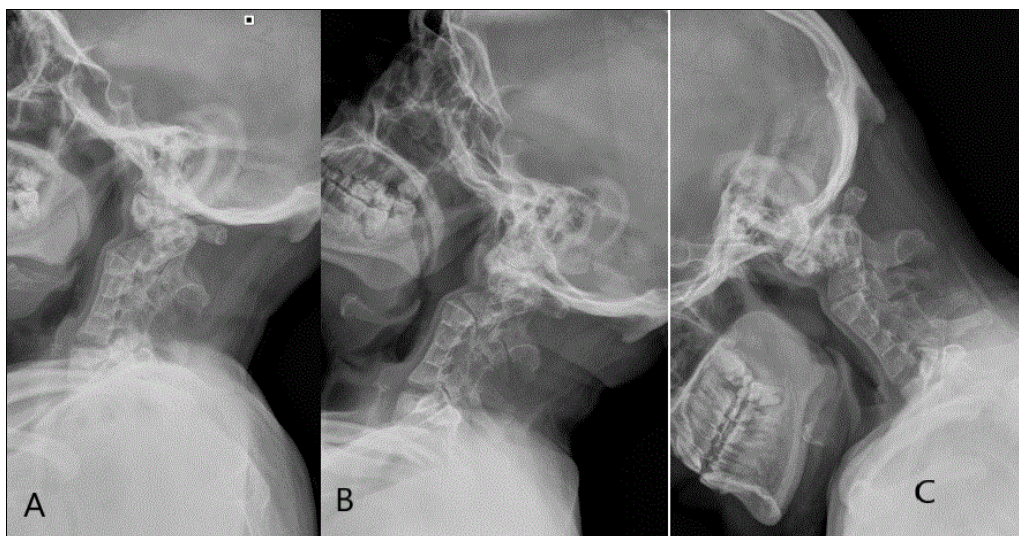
Lateral x-rays in (A) neutral, (B) extension and (C) flexion positions showing irreducibility of the AAD.
